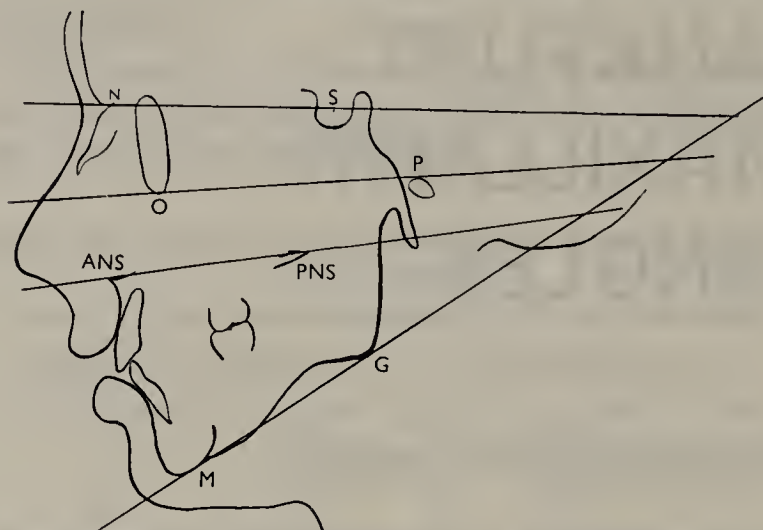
A tracing of a cephalometric radiograph showing the relevant landmarks used in the study. N, Nasion. S, Sella. O, Orbitale. P, Porion. ANS, Anterior nasal spine. PNS, Posterior nasal spine. M, Menton. G, Gonion.
